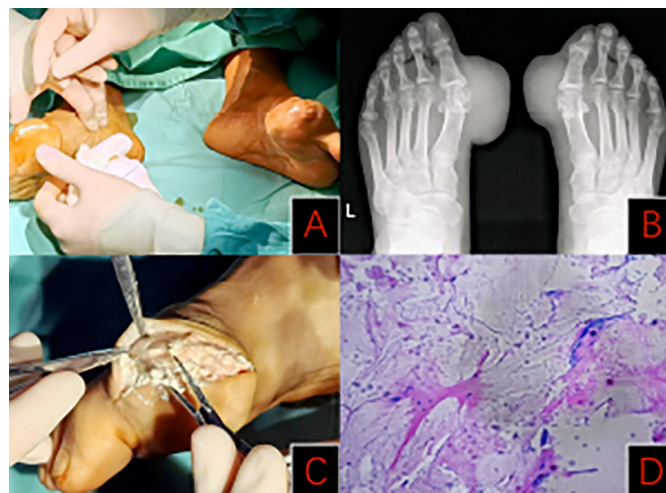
Gouty stones (A) the mass on the left foot measured approximately 6×6 cm and the mass on the right foot measured approximately 4×4 cm. (B) X-ray examination revealed a slightly dense mass at the 1st metatarsophalangeal joints of both feet, accompanied by bone destruction at the distal end of the 1st metatarsal. Given the patient's medical history, gout stones were considered as potential contributors to these observations. (C) Intraoperatively, both the foot mass and the surrounding synovium were excised. (D) Pathological examination confirmed the presence of a gout stone within the swelling.
